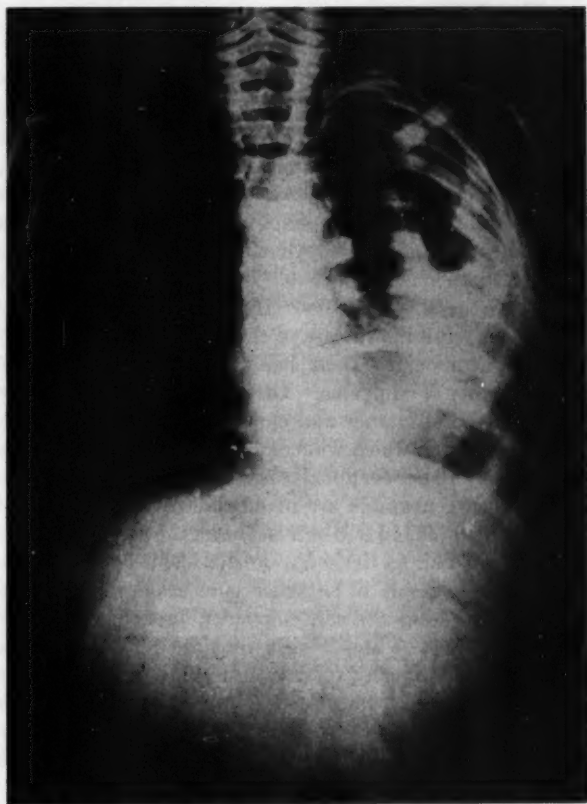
X-ray on discharge which reveals marked pleural thickening on the left and an area of pneumothorax overlying a fluid level in the middle third of the left lung field.
